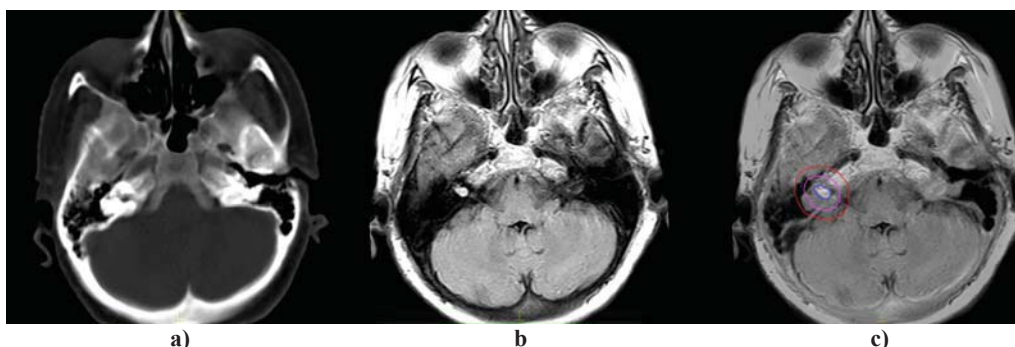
a) Computed tomography (CT) of intracranial schwannoma on the right side; b) Computed tomography – magnetic resonance imaging (CT-MRI) T2 sequence of the same section as given in 3a; c) CT-MRI fusion and delineation of target volumes.
